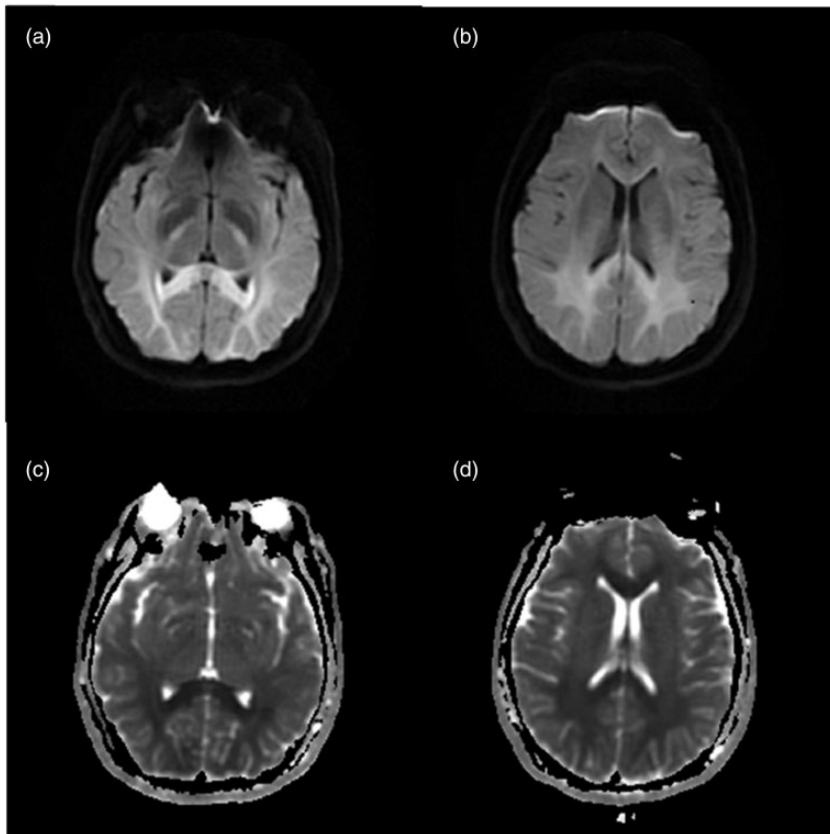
Magnetic resonance imaging of the patient. (a,b) The entire splenium of the corpus callosum, the genu of the corpus callosum, and the bilateral frontal, parietal, and occipital lobes showed high signal on cross-section diffusion-weighted imaging. (c,d) The corresponding lesions decreased on cross-section apparent diffusion coefficient imaging.
